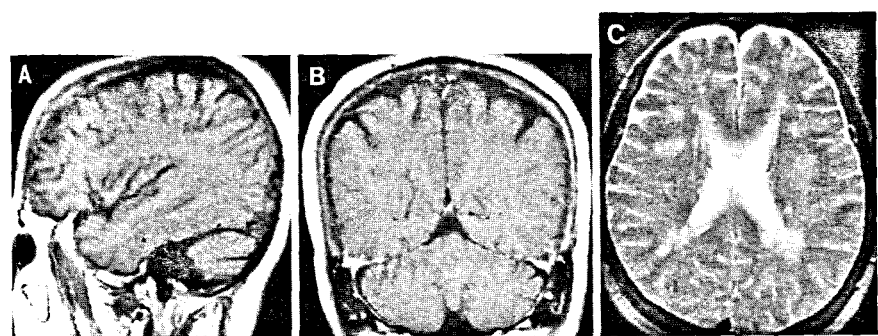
MRI scan of corresponding images in Figure 1 shows resolution of contrast-enhancing lesions on T1-weighted images on discontinuation of levamisole (A and B). Residual lesions may be seen on T2-weighted images (C).
